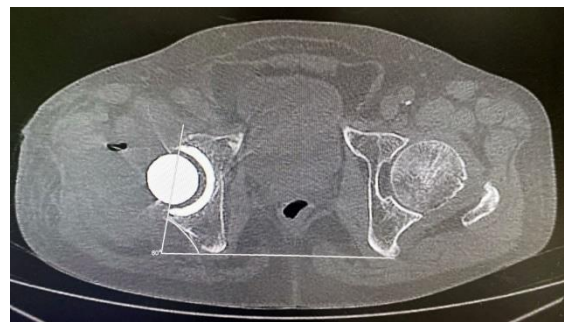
Measurement of the anatomical anteversion (AA) of the acetabular cup from an axial view of CT scans both hips.
